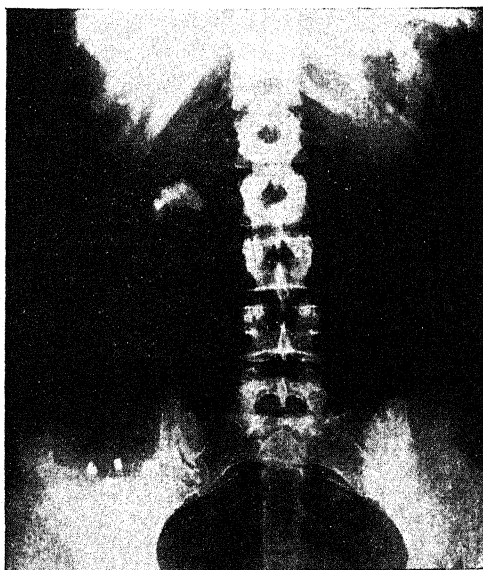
Stone in the kidney shown by the x-ray in the half-moon-shaped shadow to the left of the spine. Front view. (Waltman Walters, "Surg. Clin. of No. America," February, 1929.)
